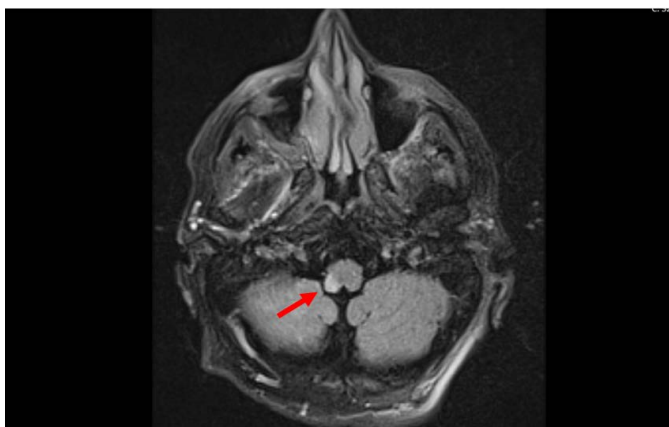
Brain MRI with an ischemic lesion in the medulla oblongata.
